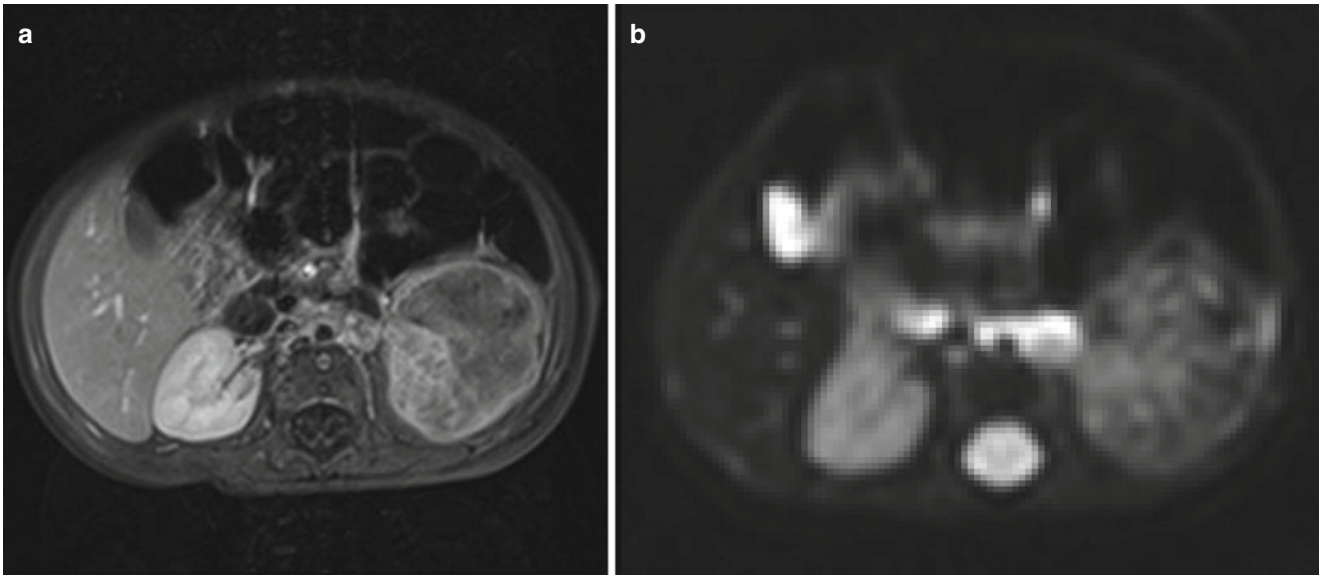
Rhabdoid tumor of the kidney. (a) A large left sided rhabdoid tumor on contrast enhanced MRI, with normal enhancement in the contralateral kidney. (b) The ADC map of the same tumor shows relatively restricted diffusion, indicating high cellularity
